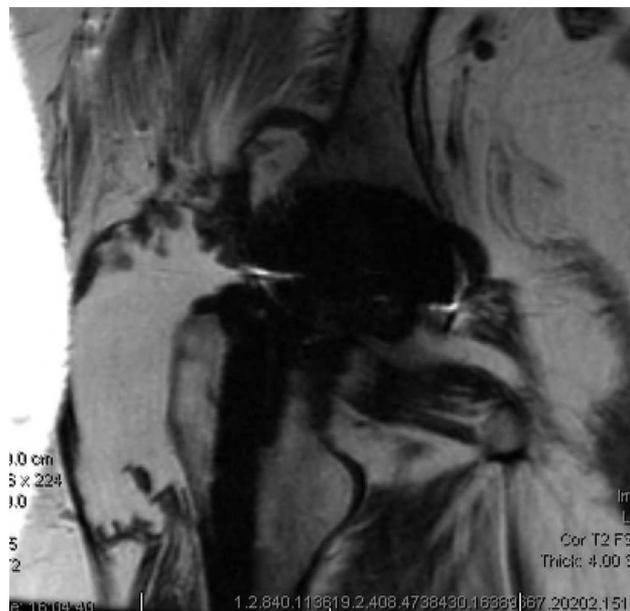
Demonstrates a MARS magnetic resonance imaging in a patient presenting with instability resulting from trunionosis. The images show a multiloculated periarticular fluid collection resulting from an adverse soft tissue reaction. MARS, metal artifact reduction sequence.
